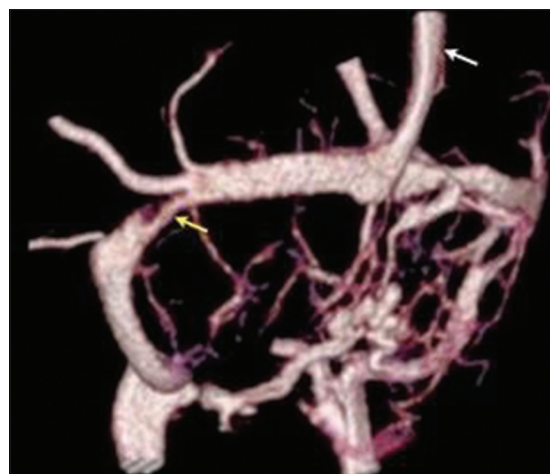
Left transverse sinus stenosis (yellow arrow) in a patient with pseudotumor cerebri, demonstrated by 320-multidetector computed tomography after lumbar puncture to lower intracranial pressure to 15 cm H₂O White arrow shows patent superior sagittal sinus
